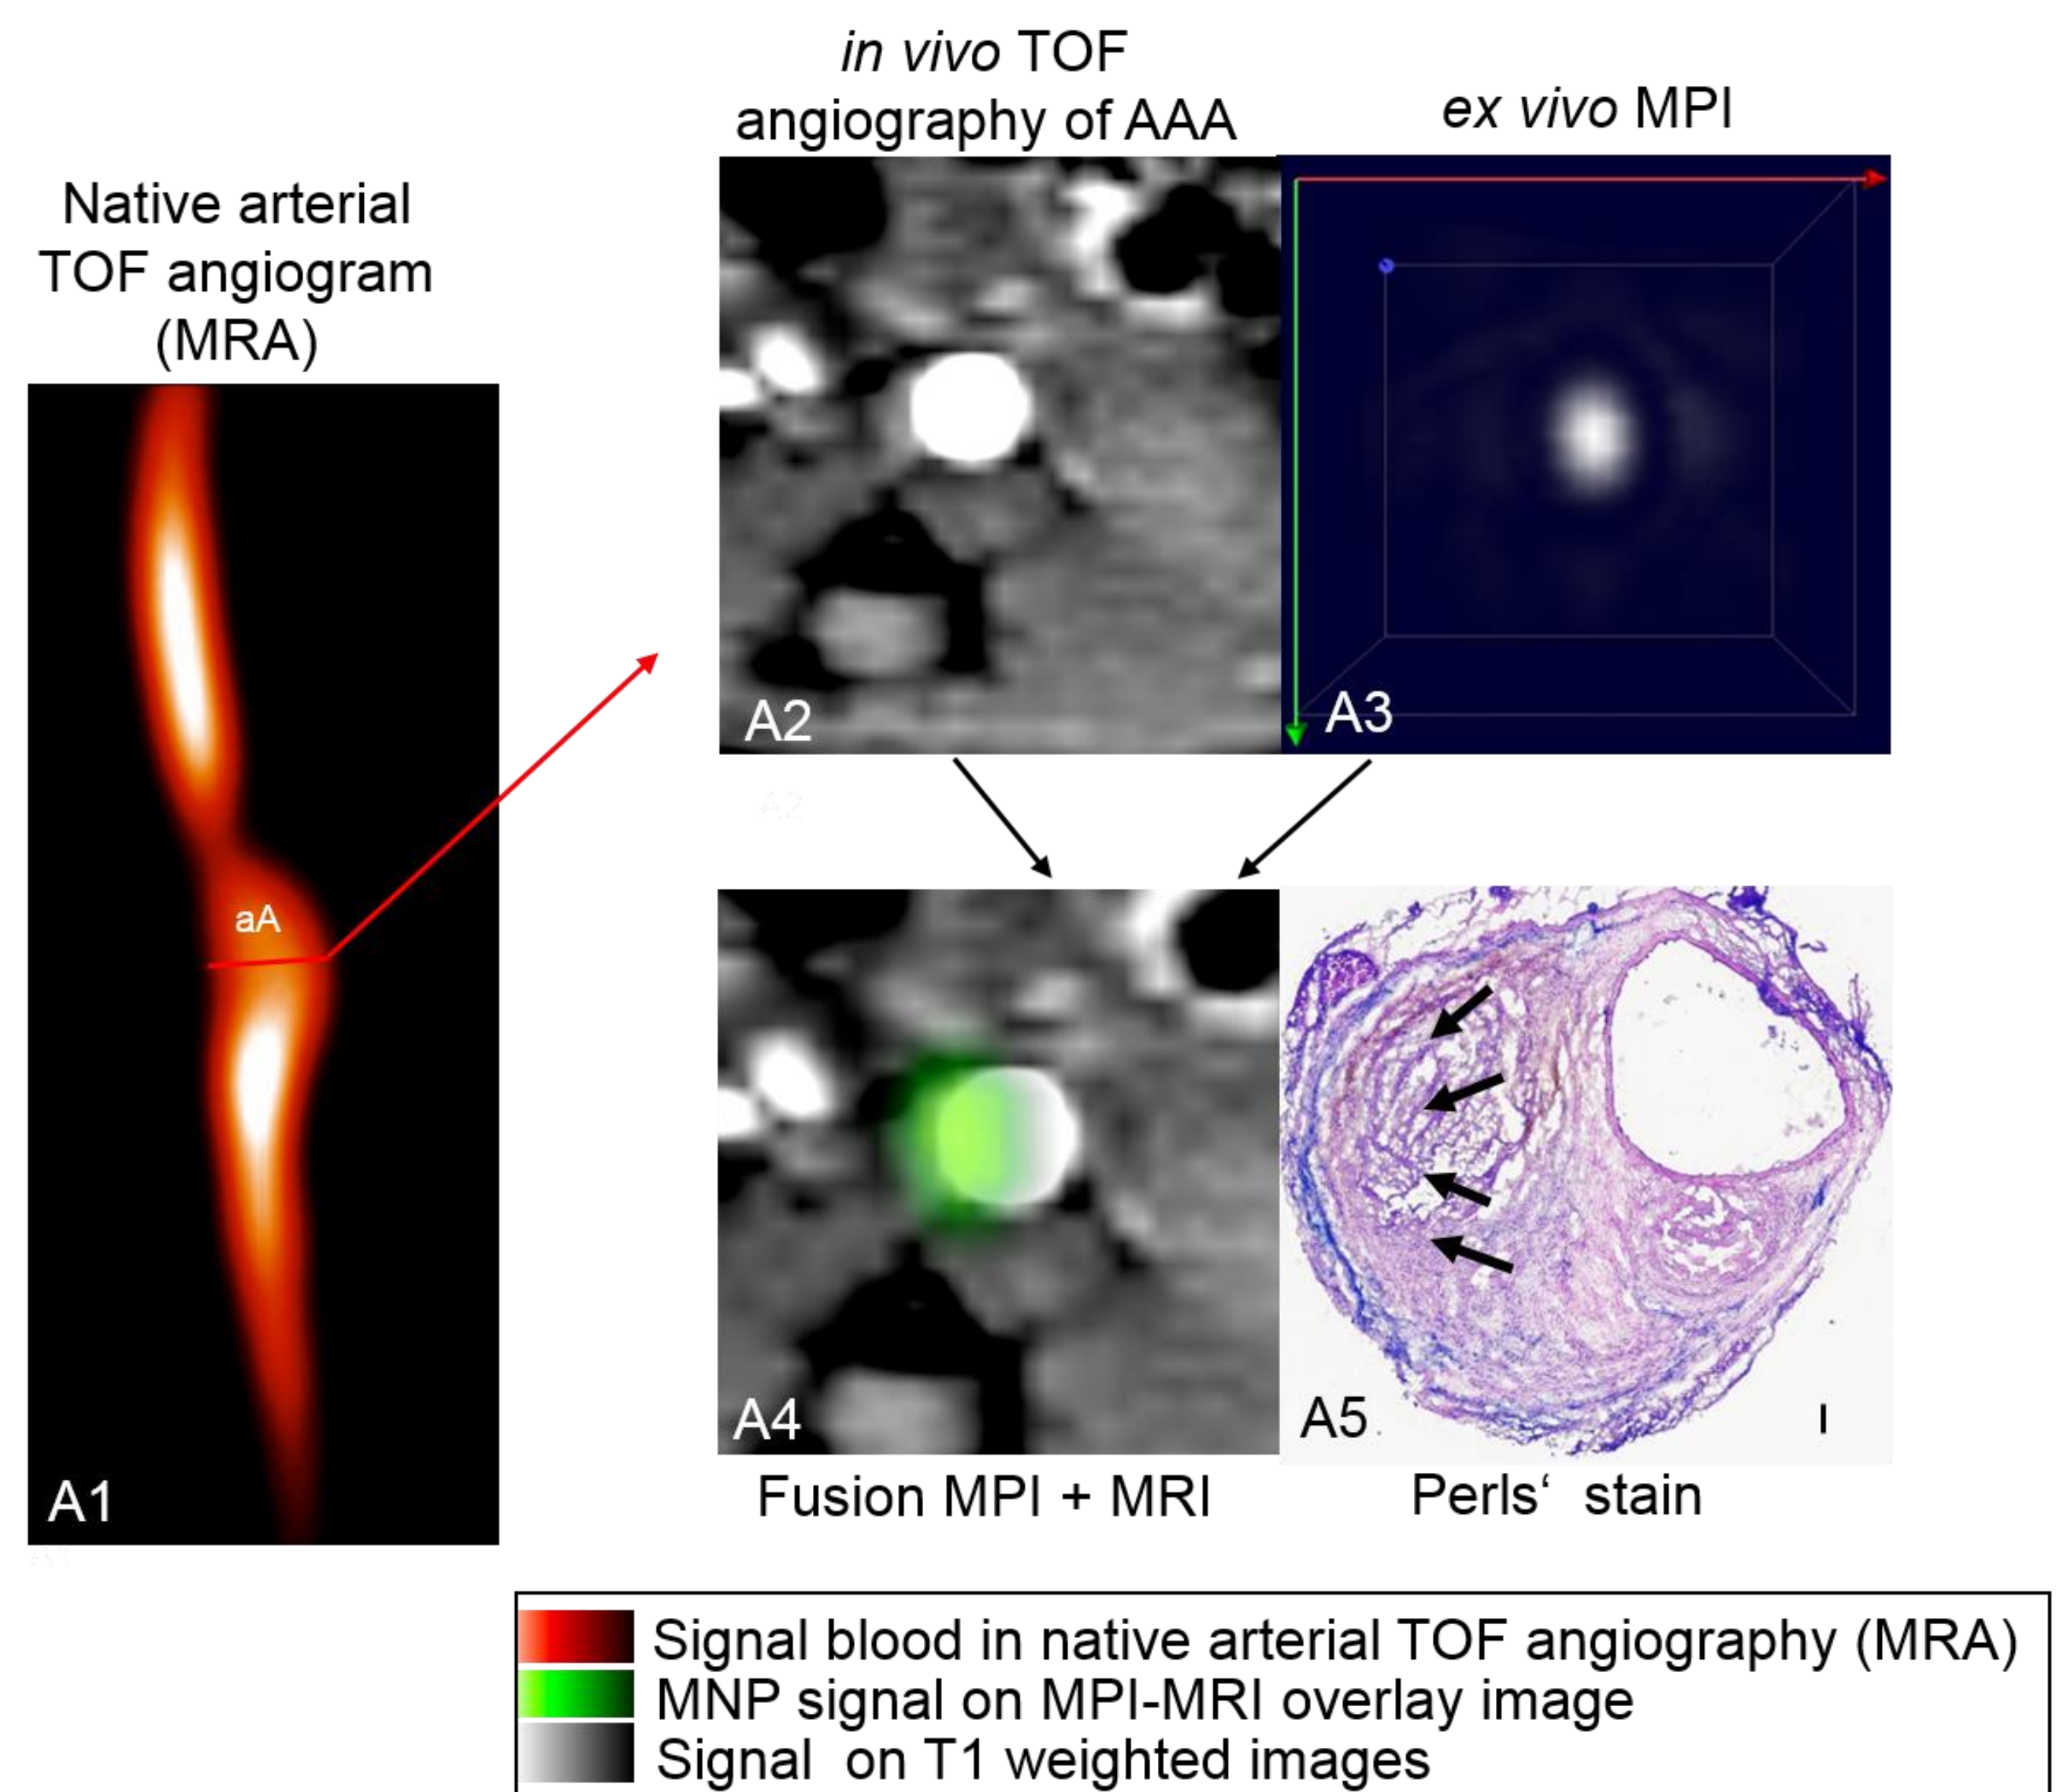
In vivo* MRI and *ex vivo* MPI of inflammatory activity during the development of AAA
